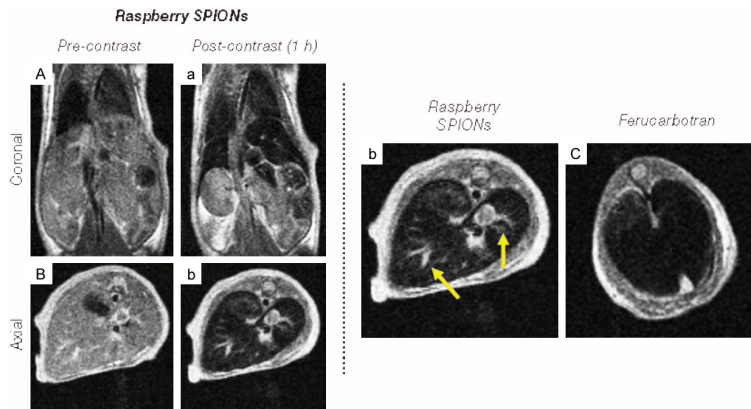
T2-weighted MRI images before and after contrast administration show raspberry SPIONs (A, B) and Ferucarbotran (C). Both agents darken the liver, but raspberry SPIONs reveal hepatic vessels (arrowed), unlike Ferucarbotran (n = 1) [52].
